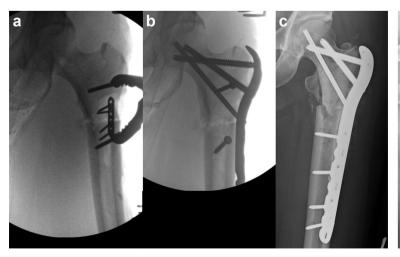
(a) Flouroscopic view of compression being applied via a Farabeuf clamp. (b) Flouroscopic view after application of the proximal femoral locking plate. (c) AP radiograph of the left hip after treatment of the bisphosphonate-related femur fracture with compression and a proximal femoral locking plate. (d) AP radiograph of a bisphosphonate-related femur fracture treated with a proximal femoral locking plate that went on to implant failure.
